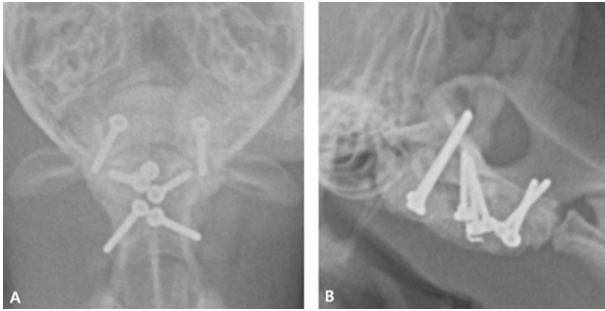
Postoperative ventrodorsal (A) and lateral (B) radiographs.
